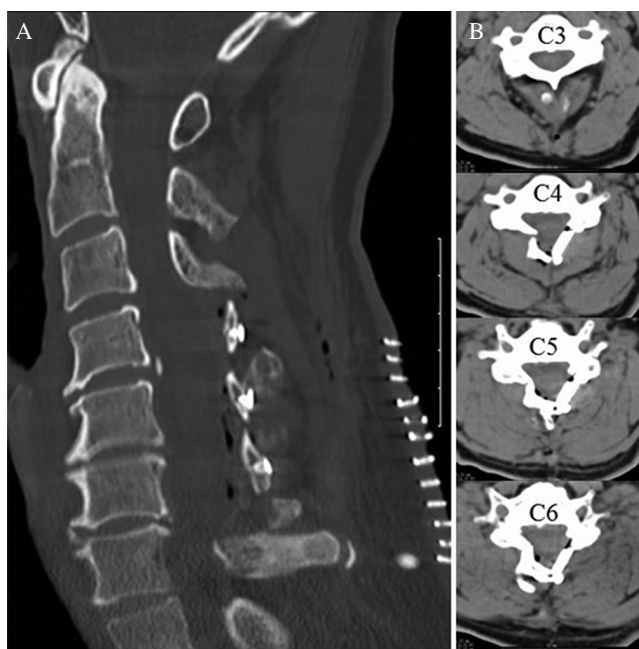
Postoperative CT scans obtained 18 h after cervical laminoplasty. (A) A sagittal image (bone window). (B) Axial images at the C3, C4, C5, and C6 levels (soft-tissue window). The cervical laminoplasty was done, and there is no sign of a hematoma.
